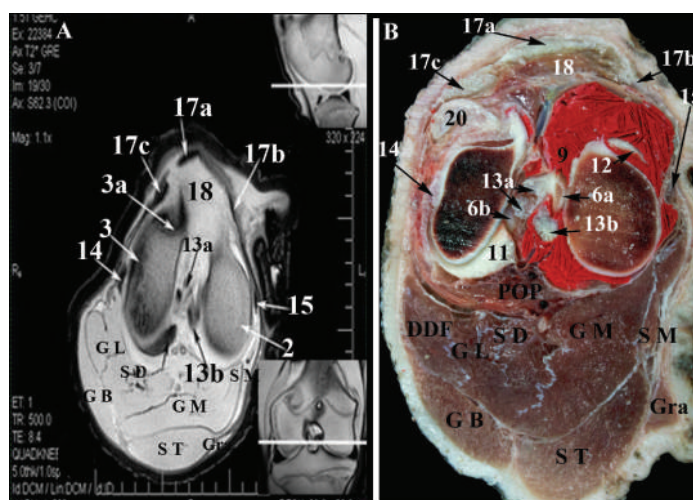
Transverse MR image (A) and gross anatomic section (B) of the left buffalo stifle at the level of the patellar apex (dorsal is up and lateral is to the left of the viewer). 1, Trochlea ossis femoris (1a, medial ridge; 1b, lateral ridge; 1c, intertrochlear groove); 2, Condylus medialis of os femoris; 3, Condylus lateralis of os femoris; 3a, Fossa extensoria; 4, Fossa intercondylaris; 5a, Apex patellae; 6, Eminentia intercondylaris ( 6a, tuberculum intercondylare mediale; 6b, tuberculum intercondylare laterale); 9, medial femorotibial synovial sac; 10, femoropatellar synovial sac; 11, Meniscus Lateralis; 11a, cranial meniscotibial ligament of the lateral meniscus; 11b, Lig. Meniscofemorale of the lateral meniscus; 12, Meniscus medialis; 12a, cranial meniscotibial ligament; 12b, caudal meniscotibial ligament; 13a, Lig. cruciatum craniale; 13b, Lig. cruciatum caudale; 14, Lig. collaterale laterae; 15, Lig. collaterale mediale; 16, Lig. popliteum obliquum; 17a, Lig. patellae intermedium; 17b, , Lig. patellae mediale; 17c, Lig. patellae laterale; 17d, Lig. femoropatellare mediale; 17e, Lig. femoropatellare laterale; 18, Corpus adiposum infrapatellare; 19, Gluteoibiceps tendon; 20, Common tendon of the extensor digitorum longus and peroneus tertius; T, proximal Extremity of the tibia; DPL, Deep popliteal lymph node; GL, M. gastrocnemius (Caput laterale); GM, M. gastrocnemius (Caput mediale); SD, M. flexor digitorum superficialis; POP, M. popliteus; GB, M. gluteoibiceps femoris; ST, M. semitendinosus; SM, M. semimembranosus; Gra, M. gracilis.
